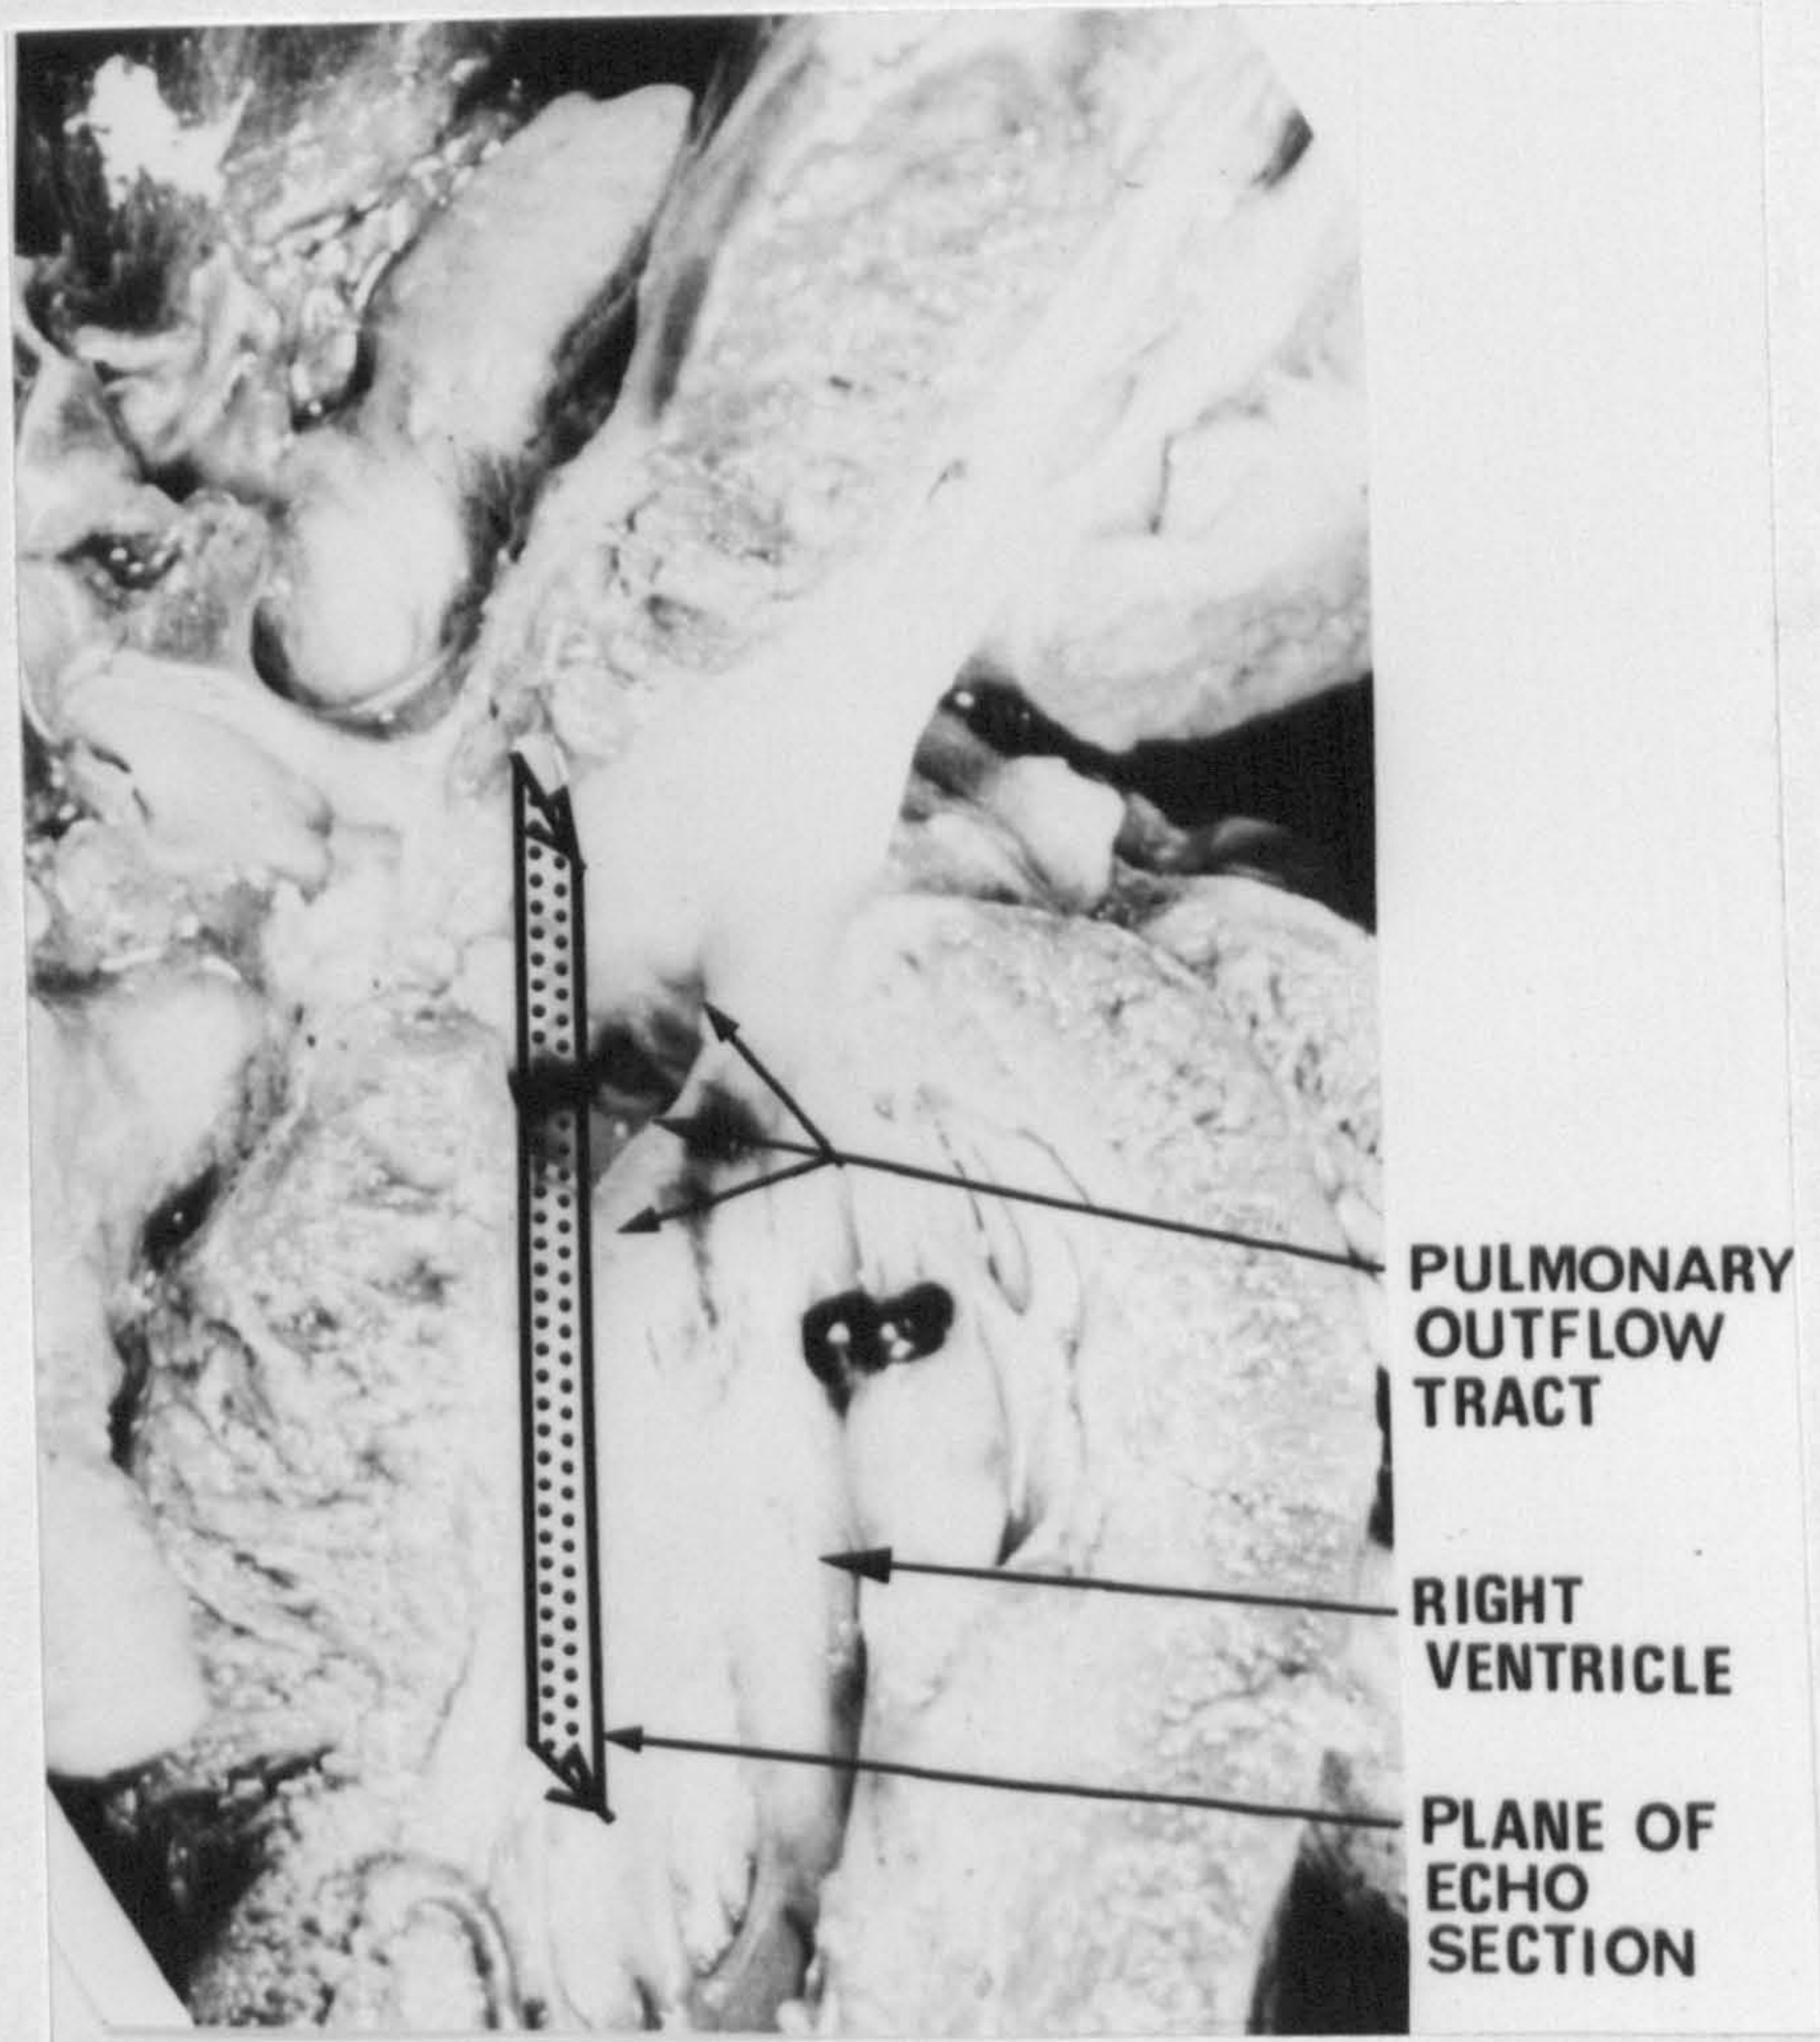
Case 2. The front of the right ventricle is incised and elevated to display the narrowed pulmonary outflow tract. The plane of the echocardiographic section marked is that seen in Figure 11.2. cutting through the pulmonary outflow tract with the left ventricle behind.
